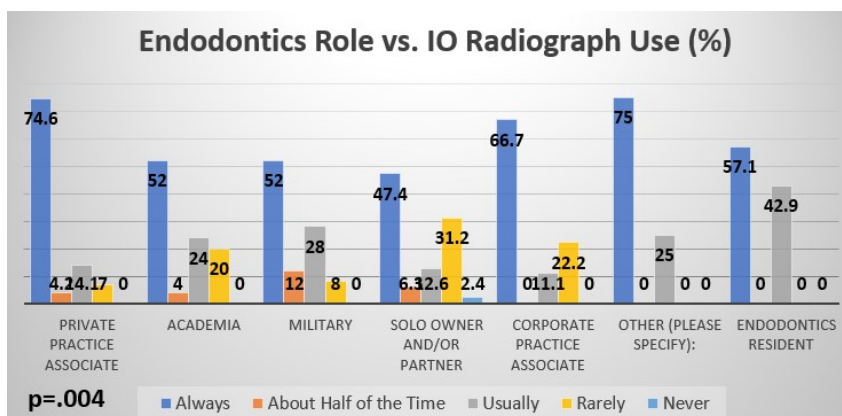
Chi-square data comparing the PR and the use of intra-operative radiographs.
